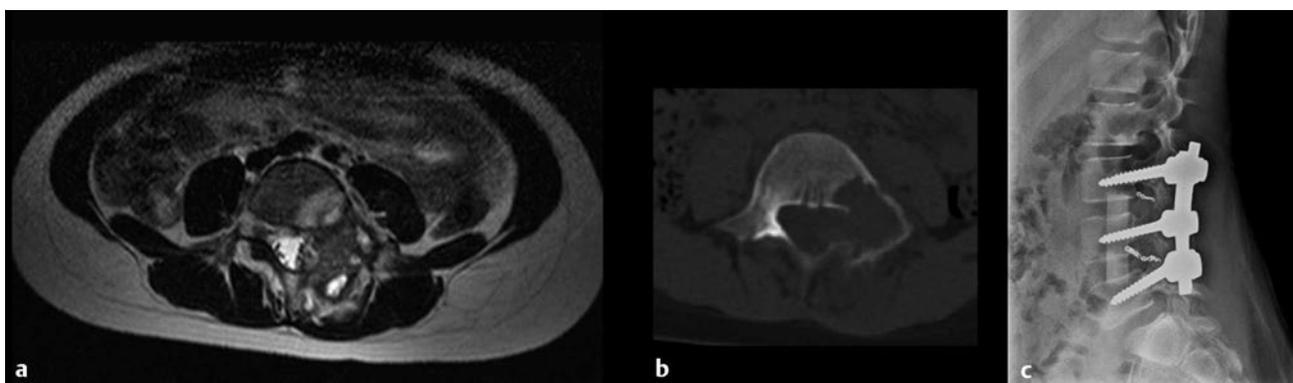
This 8-year-old girl presented with persistent back pain that extended down the left lower extremity. She had paraspinal tenderness and weakness of the left dorsiflexors. (a) T2-weighted magnetic resonance imaging demonstrates a complex mass involving the lamina, pedicle, and vertebral body of L4, consistent with aneurysmal bone cyst. (b) Computed tomographic scan shows a thin rim of cortical bone. Preoperative angiography and embolization were performed. (c) The lesion was removed by a posterior approach, and primary reconstruction was performed with allograft and posterolateral fusion (note coils from embolization). (Courtesy of Dr. Joseph Dryer, New York University.)
